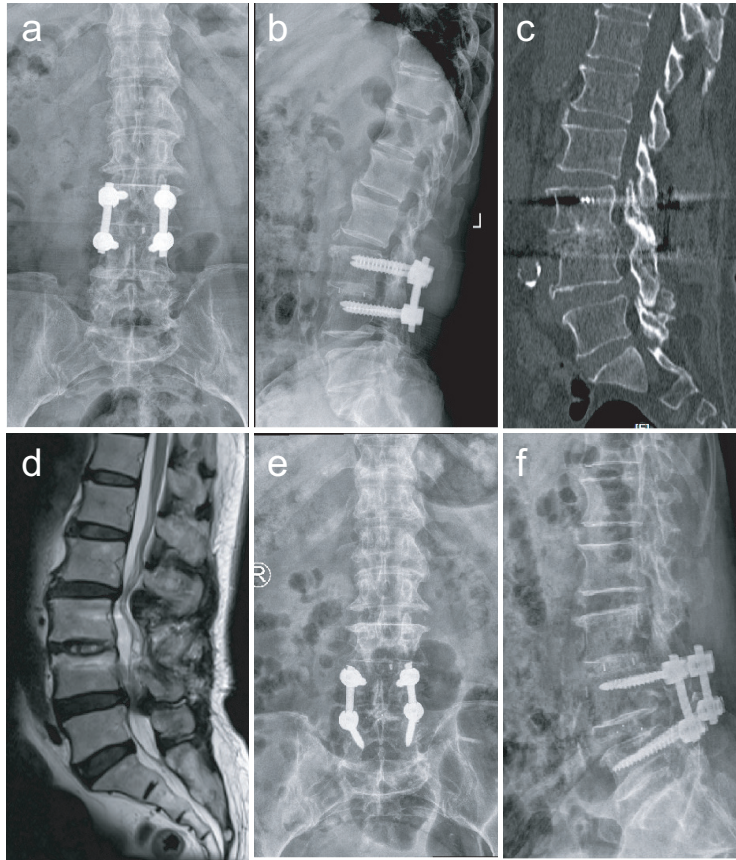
Images obtained from female patient, 70 years old, had experienced lower back pain for 1 year, which had worsened with right leg radicular pain for 5 months. Both lower back and leg pain could be improved while at rest. The patient had undergone L3-4 transforaminal lumbar interbody fusion (TLIF) 8 years ago. The preoperative lumbar spinal AP (anterior-posterior), lateral view (a, b) have shown primary L3-4 TLIF fixators; The sagittal CT reconstruction (c) have indicated complete fusion at L3-4 level and no obvious calcification was observed at L4-5 intervertebral disc; the lumbar MRI (e) have shown L4-5 lumbar stenosis; The patient underwent L3-4 internal fixators were removed and L4-5 TLIF surgery. The postoperative AP and lateral view (f, g) of the lumbar spine have shown appropriate position of internal fixators. The patient's preoperative syndrome were improved instantly after the revision surgery.
